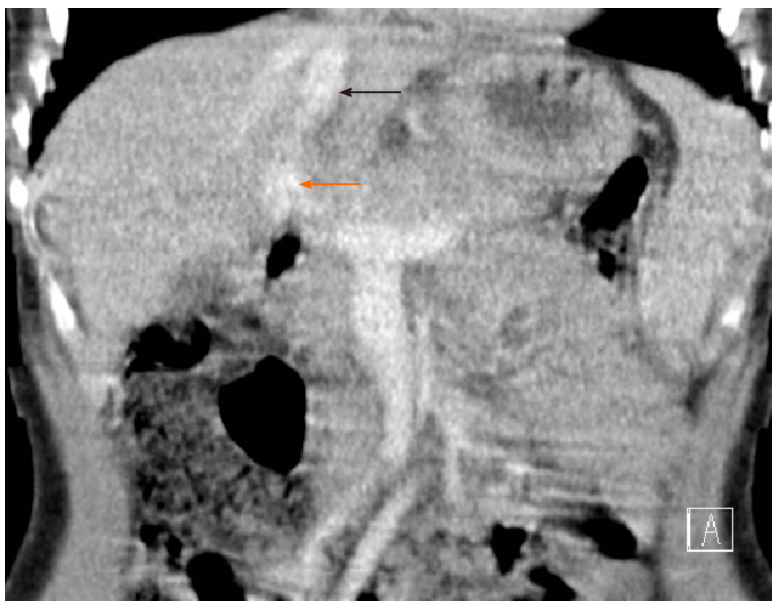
Abdominal computed tomography image of the intrahepatic portosystemic shunt (case 1). The left portal vein (orange arrow) flows directly into the left hepatic vein (black arrow).
